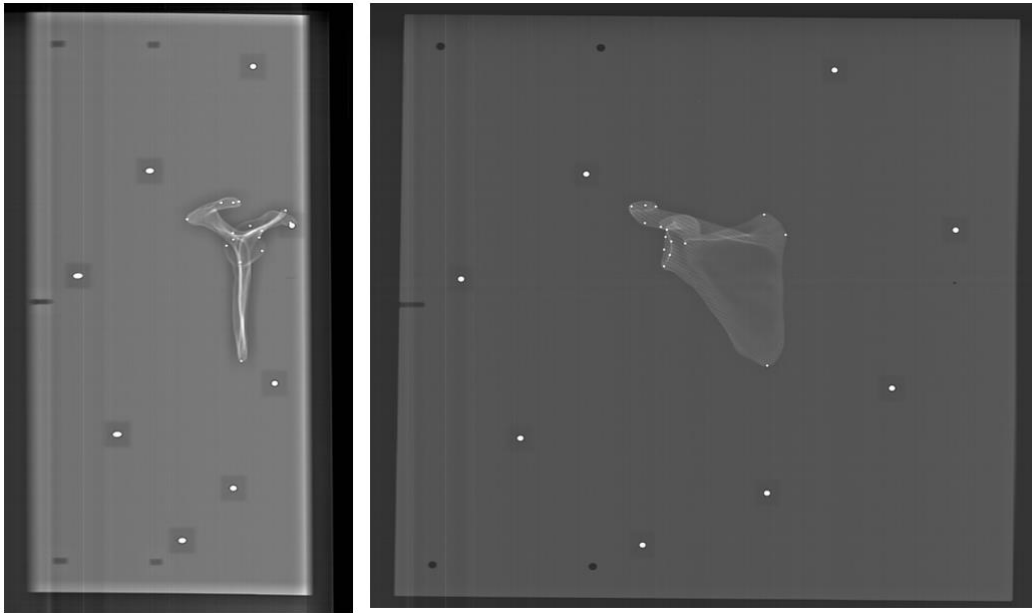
Bi-planar 2D X-ray images of the 3D printed scapula with small ball bearings located at sixteen landmarks for 3D coordinates reconstruction.
